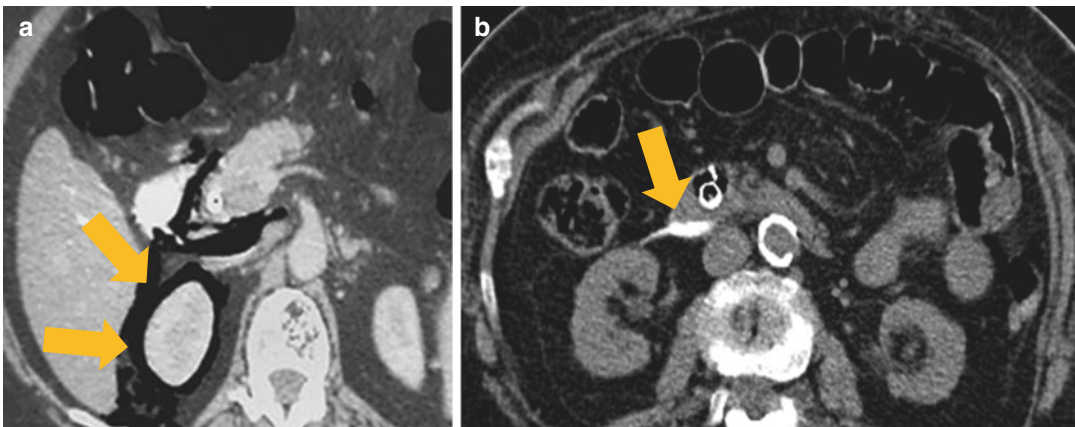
(a and b) Presence of pararenal free air (a) and retroperitoneal extravasation of medium contrast (b) at the abdominal CT scan
